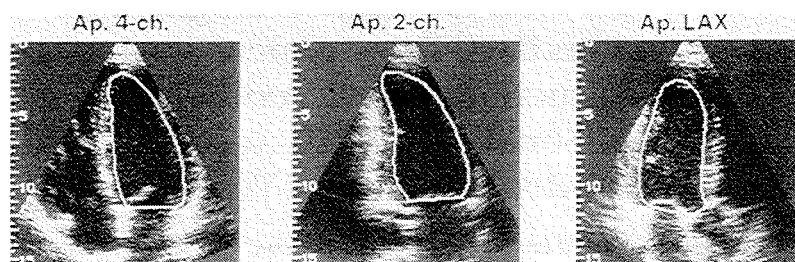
Two-dimensional ultrasound images of left ventricle in end-diastole obtained from apical position. *From left to right:* apical four-chamber, long-axis (two-chamber), and long-axis imaging planes. Endocardial traces are shown as *white continuous lines*. Numbers indicate distance from transducer in centimeters.
